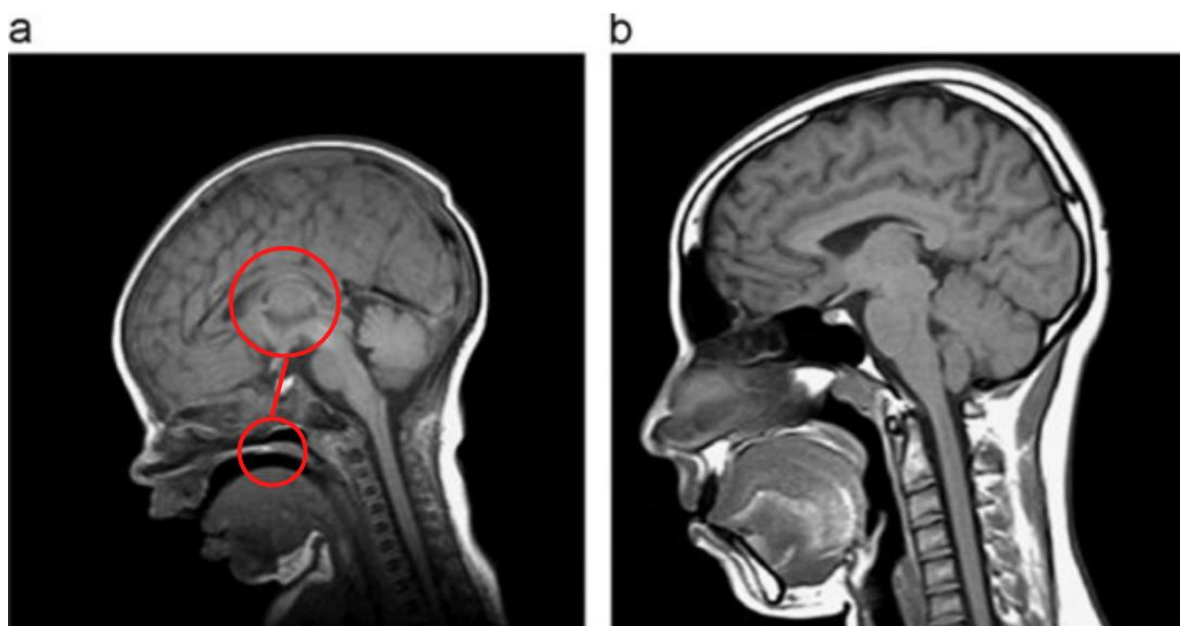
(a) Mid-sagittal T1 MR images of an infant's brain at the age of 39 weeks, five days, GA at birth, that was one day old at the time of the scan. (b) An adult brain. Reprinted from *Computers in Biology and Medicine*, Volume 64, Chelli N. Devi, Anupama
